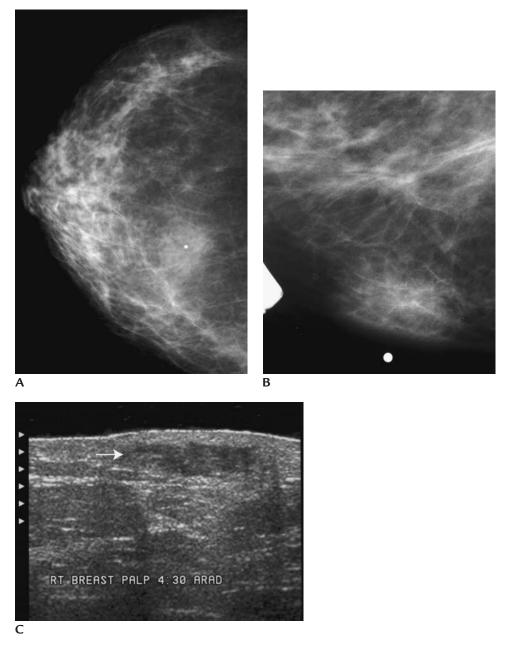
Sebaceous cyst. (A) Round, isodense palpable (metallic BB) mass with indistinct margins in the medial aspect of the right breast. (B) Spot tangential view demonstrating palpable mass (metallic BB) with ill defined margins associated with the skin. (C) On ultrasound, an irregular, hypoechoic mass (*arrow*) with indistinct margins is imaged, arising in the dermal layer and causing focal thickening of the skin.
